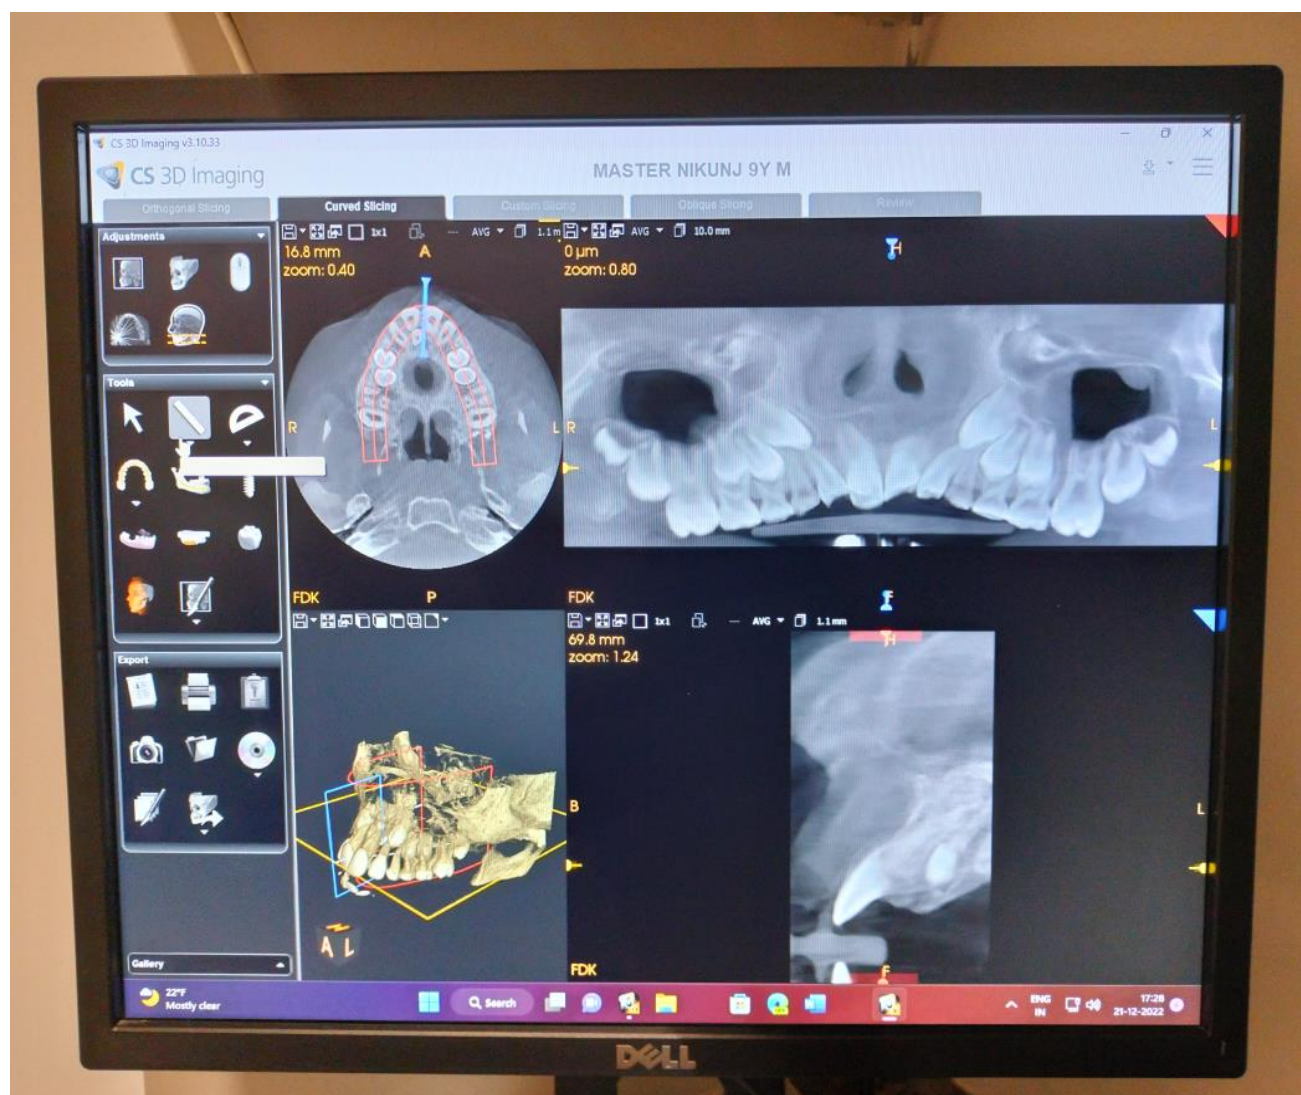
CBCT images viewed by CS-3D imaging software viewer
